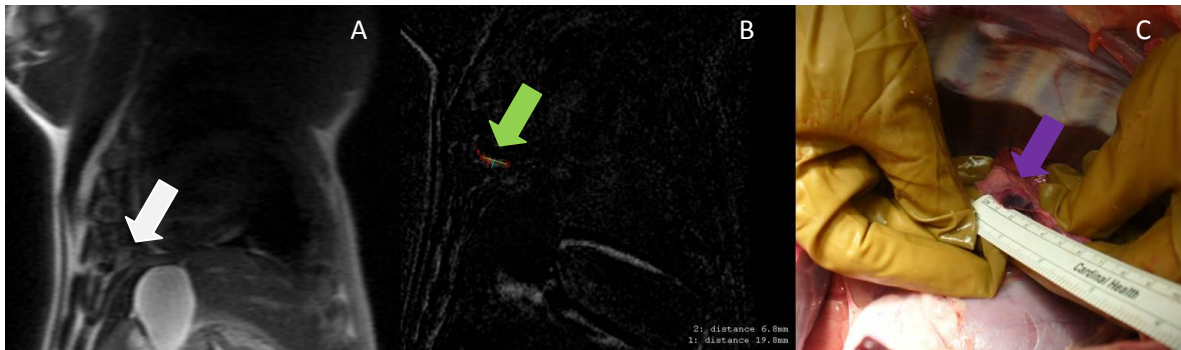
A: MR image (Localizer) used for treatment planning in the pleura (white arrow) B: Post-ablation MRI (subtraction of LAVA images before and after ablation), showing a very small ablated area near the diaphragm (green arrow); C: Necropsy image showing the ablated area in the pleura (purple arrow).
